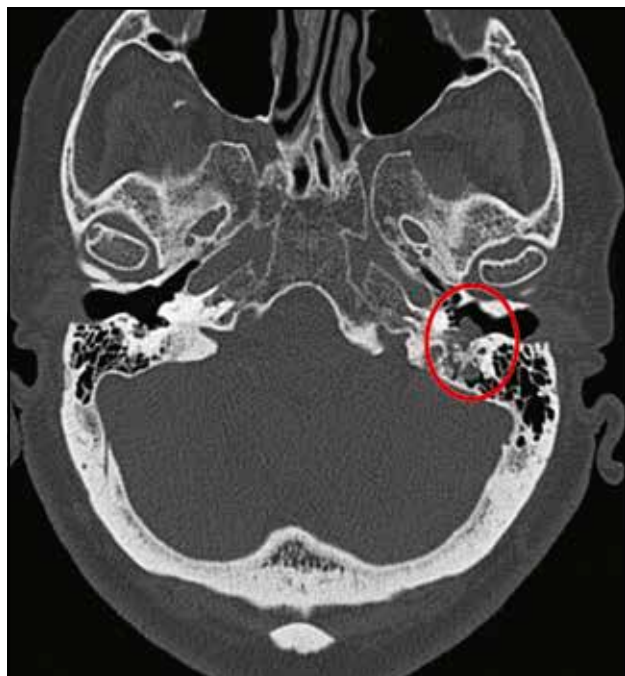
Cranio-facial CT scan, axial slice, left jugulotympanic paraganglioma.
